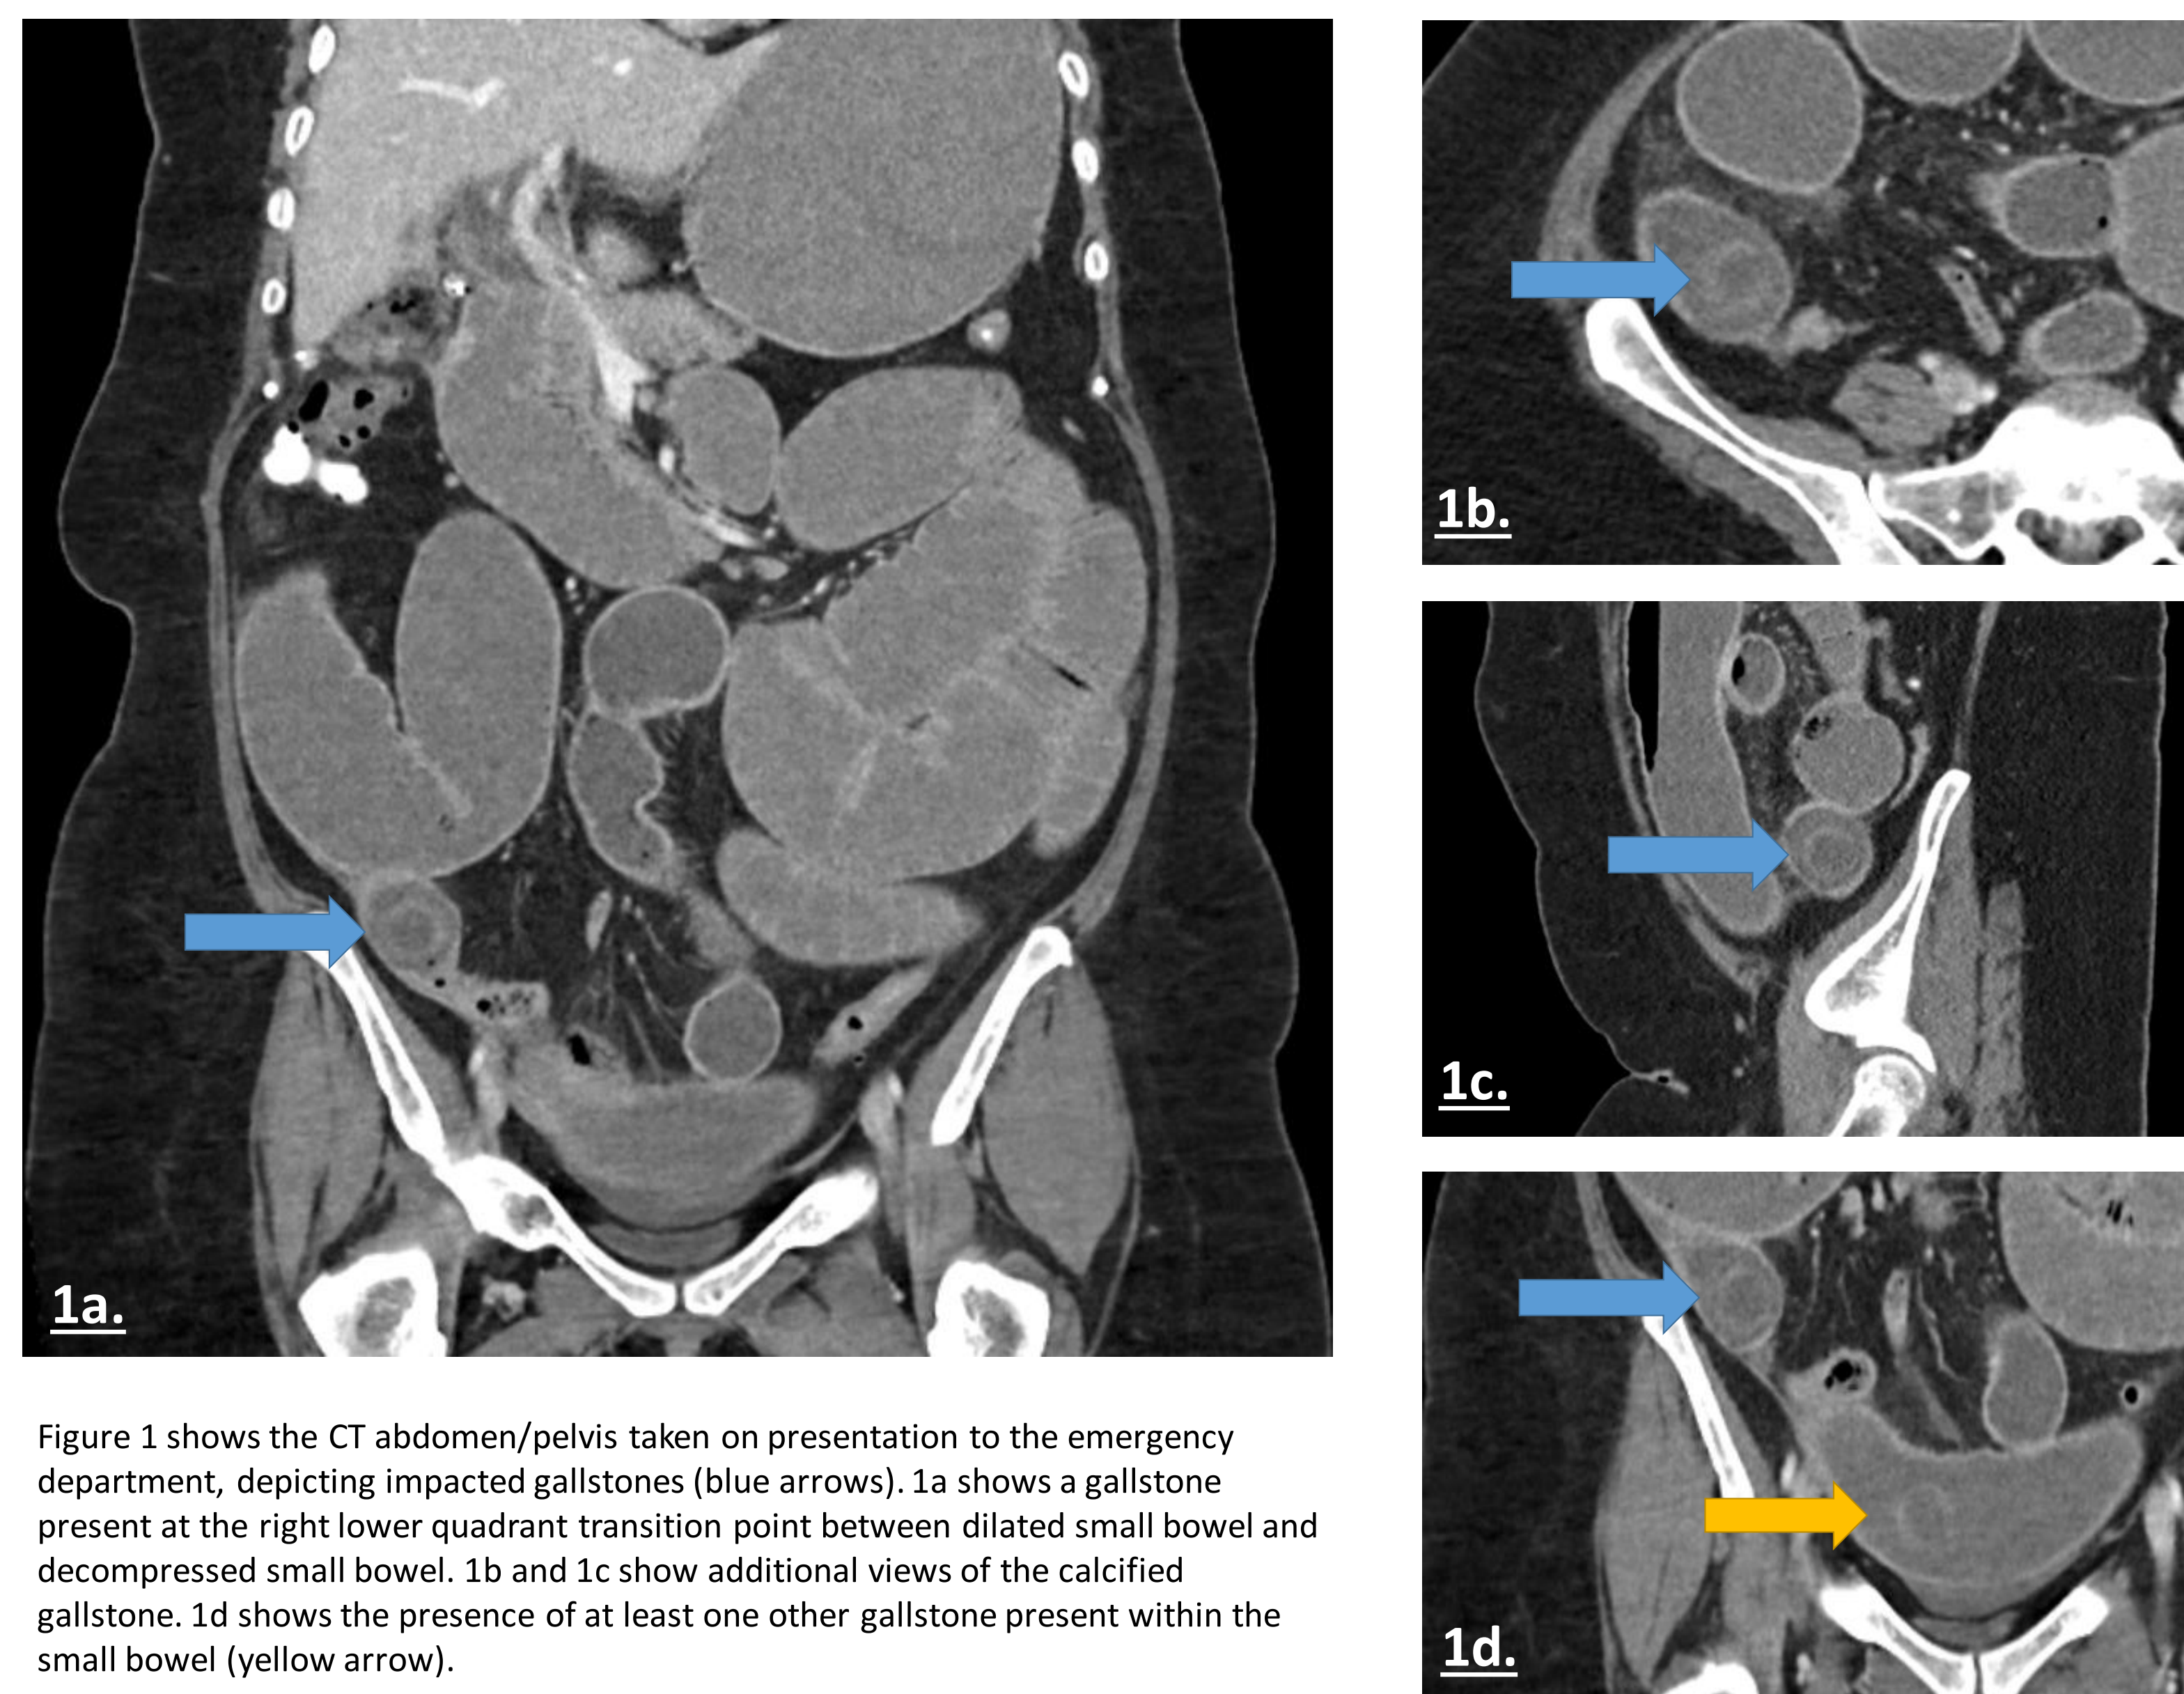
shows the CT abdomen/pelvis taken on presentation to the emergency department, depicting impacted gallstones (blue arrows). 1a shows a gallstone present at the right lower quadrant transition point between dilated small bowel and decompressed small bowel. 1b and 1c show additional views of the calcified gallstone. 1d shows the presence of at least one other gallstone present within the small bowel (yellow arrow).
